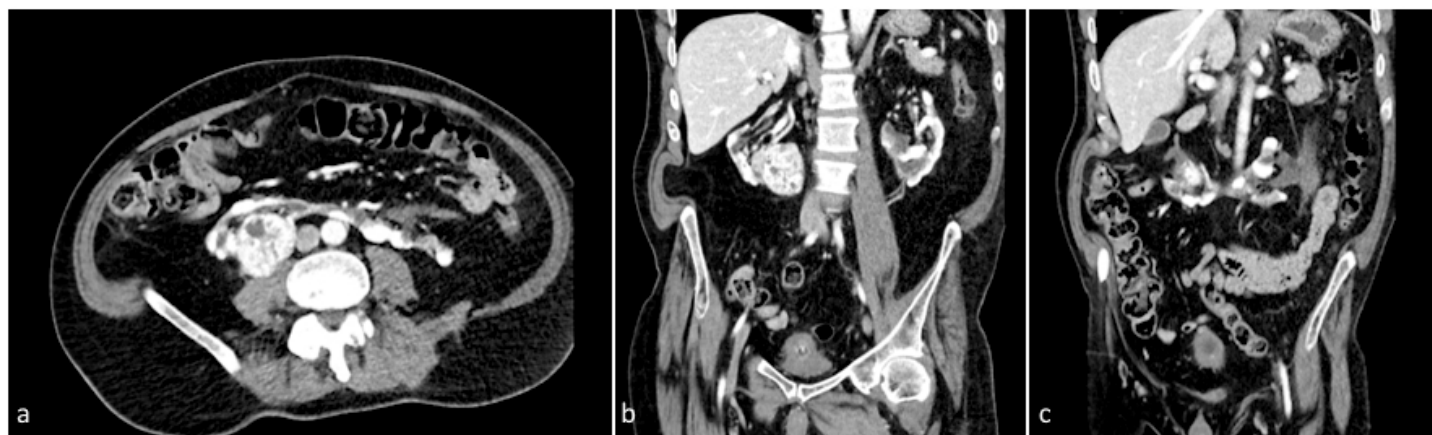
(a) Axial view of RCC in right moiety of the horseshoe kidney on abdominal CT, (b) Coronal view of RCC in right moiety of the horseshoe kidney on abdominal CT, highlighting its exophytic location, (c) CT enhanced coronal view on the isthmus and relation to the tumour
